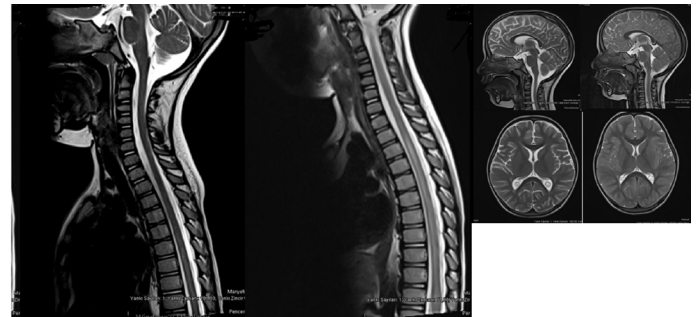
T2 flair hyperintense foci were observed in deep gray matter and white matter levels in both cerebral hemispheres, and large areas of involvement were observed in posterior part of pons and in both cerebral hemispheres. T2 hyper intensity was observed in the whole medulla spinalis starting from T4 level and inflammation-demyelinating foci in the spinal cord were found to be compatible with ADEM in the foreground. Spinal and Cranial MR images of patient on first day and 15th day of hospitalization shown from left to right.
